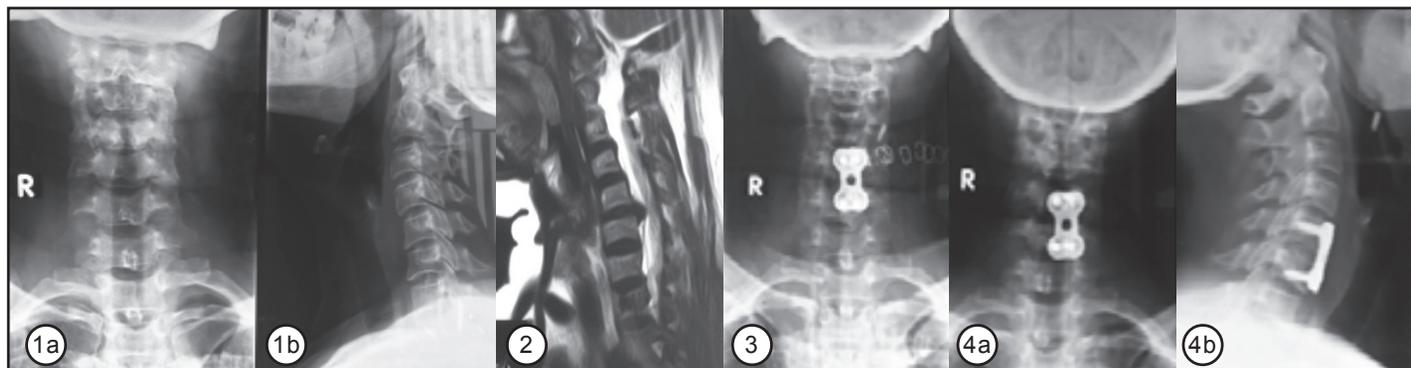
Pre-operative X-Ray; Figure 2: Pre-op MRI showing IVDP C5-C6; Figure 3: Post-op X Ray with iliac bone graft; Figure 4a & 4b: Follow up X Ray showing fusion of C5-C6 at 6 months follow up.
